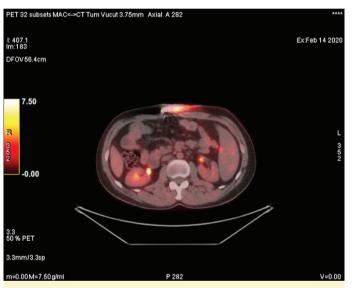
Relatively mild, linear false-positive FDG uptake in the driveline.
